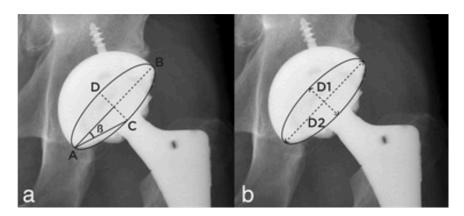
Measurement of acetabular anteversion in a plain anteroposterior radiograph using (a) Liaw's or (b) Lewinnek's method.
